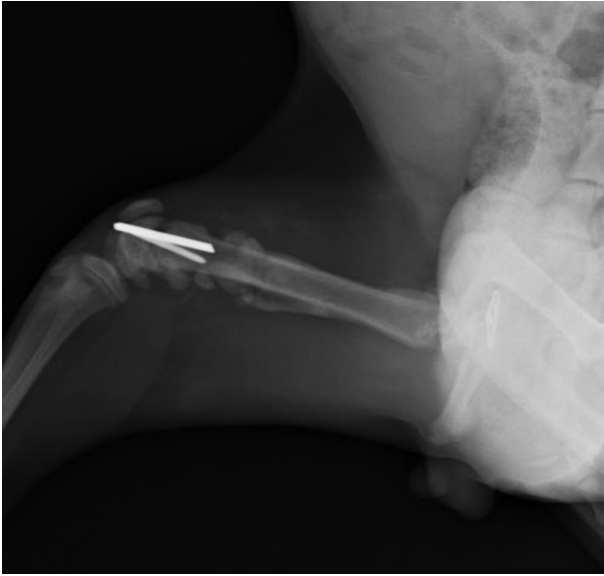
Postoperative 3rd week ML radiograph
